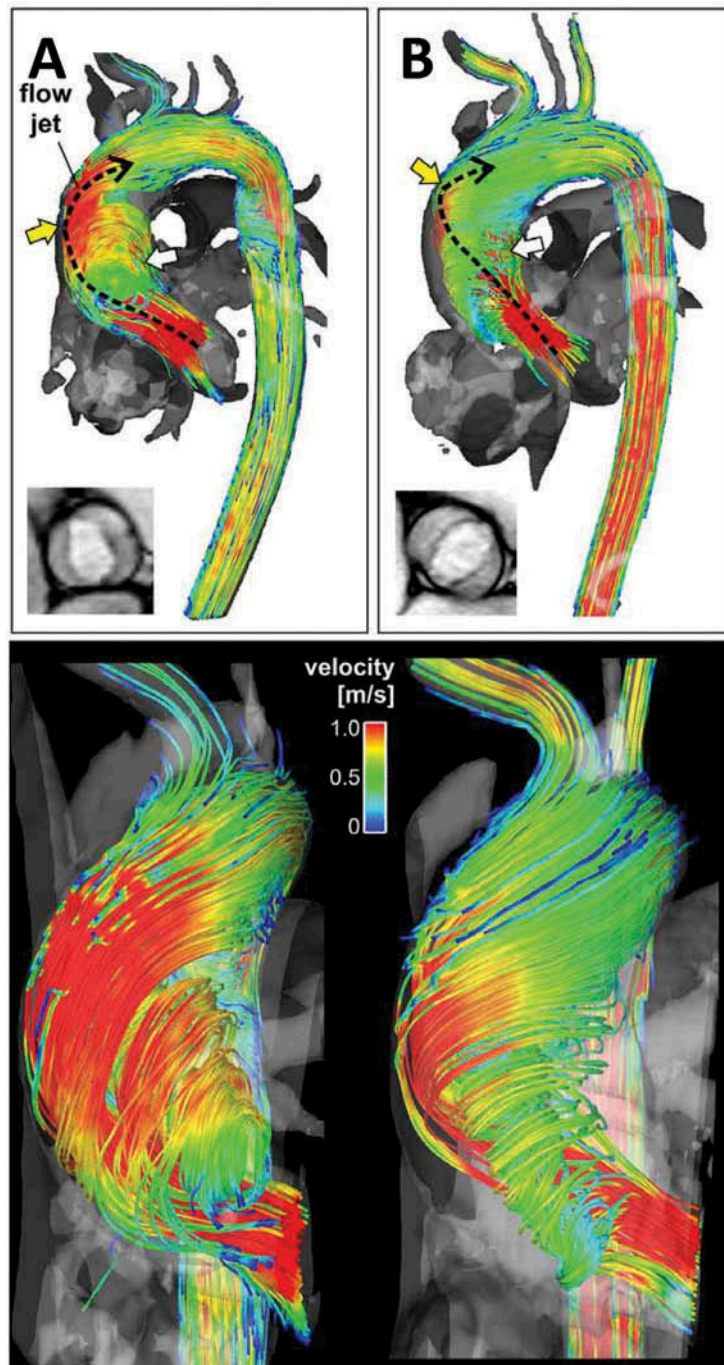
Altered aortic flow patterns in bicuspid aortic valve resulting in increased wall shear stress and resultant aortic dilatation as characterized by 4-dimensional flow cardiovascular magnetic resonance imaging. In panel A, an example of a bicuspid aortic valve (BAV) with fusion between the right and the left coronary cusps is shown. In panel B, a type 0 BAV with orientation of the commissures anteroposterior is shown. The 3-dimensional streamline visualization of the peak systolic blood flow (dashed lines) indicate different wall impingement zones of the outflow jets (yellow arrows) for the different morphologies of BAV. The 3-dimensional flow patterns are presented in the panels below. (Reproduced from R. Mahadevia et al., Bicuspid Aortic Cusp Fusion Morphology Alters Aortic Three-Dimensional Outflow Patterns, Wall Shear Stress, and Expression of Aortopathy, *Circulation*, 129(6), © 2014, with permission from Wolters Kluwer Health, Inc.).
